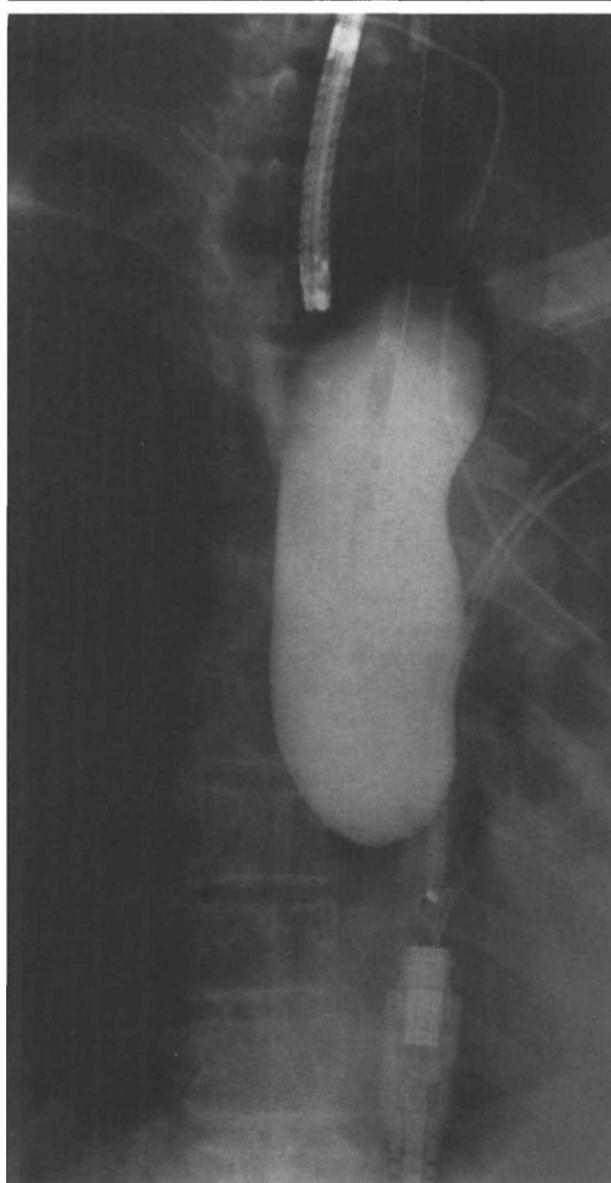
The X-ray shows that the balloon inserted in the esophagus, inflated with air and iodine solution, sealing the fistula. The position of the balloon was also confirmed by fiberoptic bronchoscopy.
